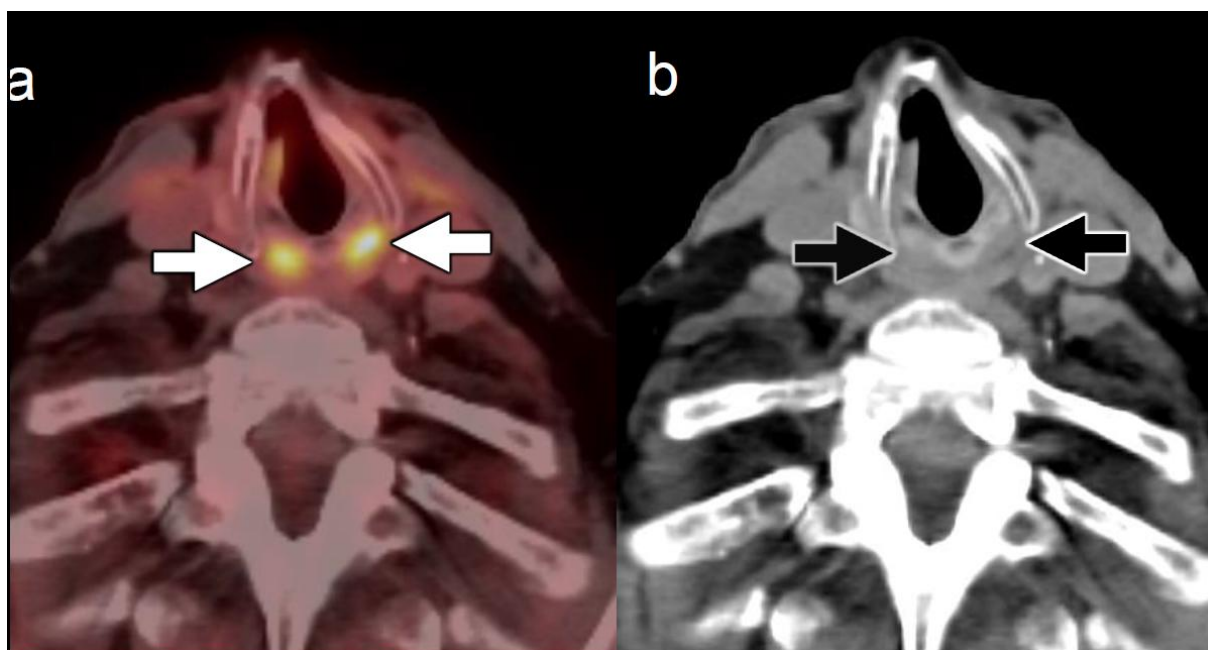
Voluntary muscular activity with FDG uptake. Fused axial PET/CT (a) shows bilateral FDG avidity (white arrows) posterior to the cricoid. Axial NECT (b) shows normal appearance of the postcricoid region bilaterally (black arrows), confirming that the FDG uptake was related to phonation activity involving the posterior cricoarytenoid muscles.
